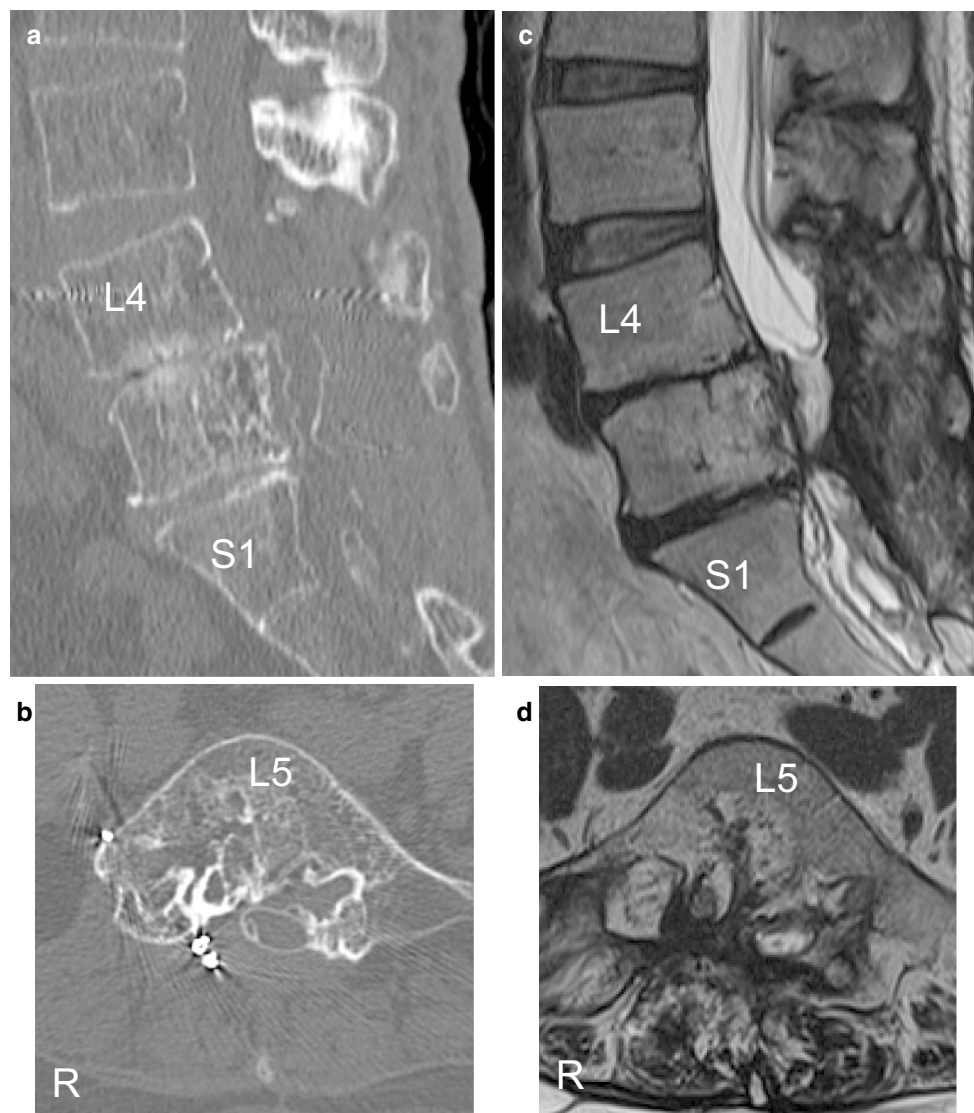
Images at postoperative year 8. Sagittal (a) and axial (b) views of computed tomography. Sagittal (c) and axial (d) views of T2-weighted magnetic resonance images
